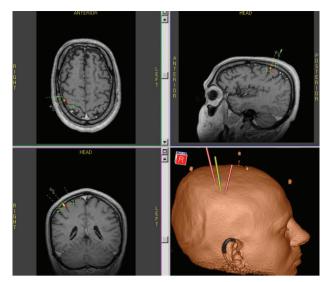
Magnetic resonance image (MRI) demonstrating the target site for motor cortex stimulation.
